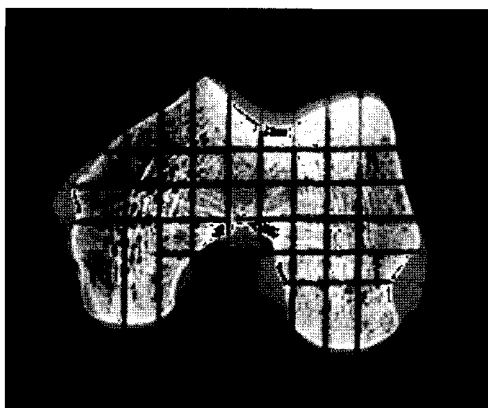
CT scan of femur
